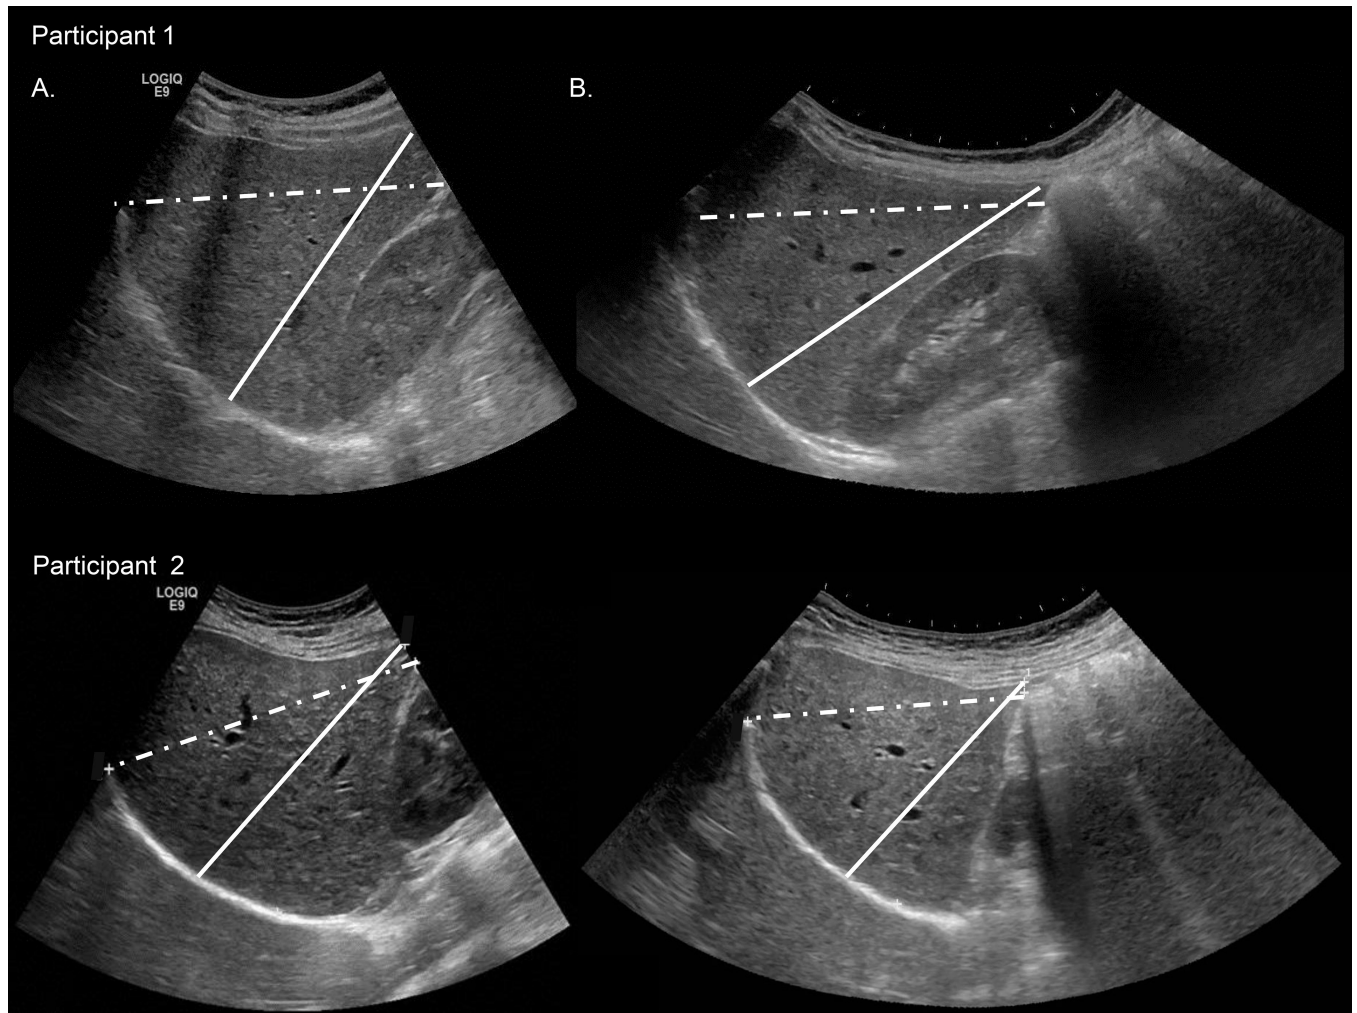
Right liver lobe (RLL) measurements by ultrasound.
